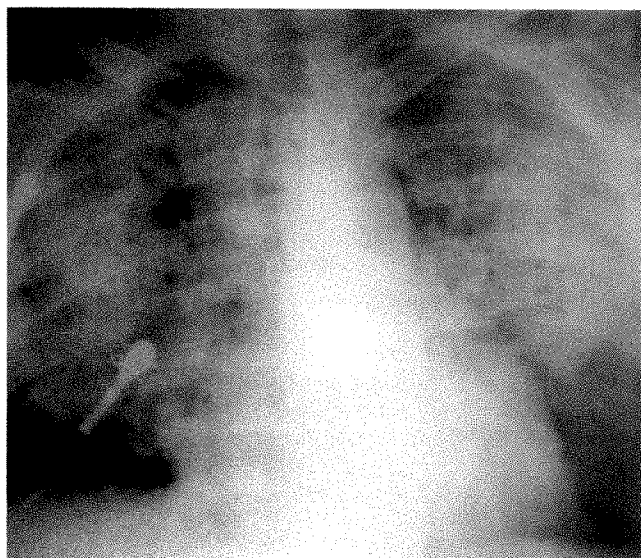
51-year-old man with metastatic renal cell carcinoma whose condition deteriorated 15 days after therapy was started. Chest radiograph shows diffuse air-space disease. Patient required intubation and bilateral chest tubes for pneumothoraces.
